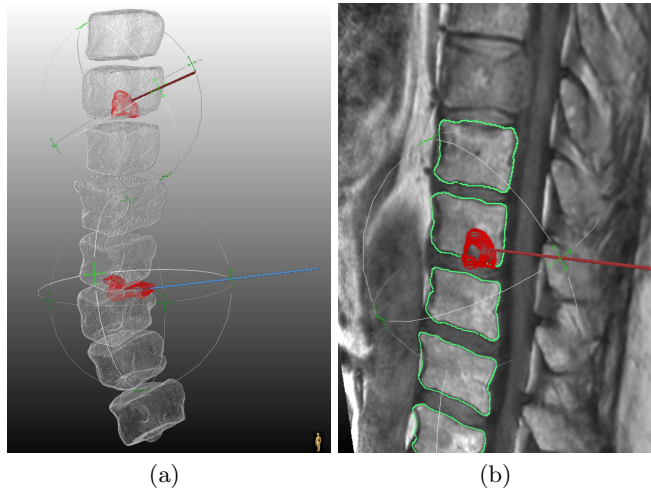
Details of the volume-rendered scene with applicator model tips placed within the metastases. It is possible to display only the segmented 3D objects with the placed applicator models (a), as well as to add further anatomical and structural information by displaying also the original MRI data (b). Therefore, the user could balance between simplified and more complex visualisations.
